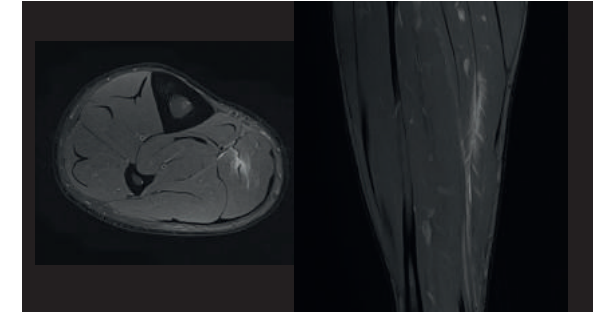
(Case #8). MTJ strain of medial aponeurotic fascicle of the soleus muscle. MRI signs included oedema, aponeurotic disruption, minimal intermuscular fluid/haemorrhage, and mild loss of the aponeurosis tension.
